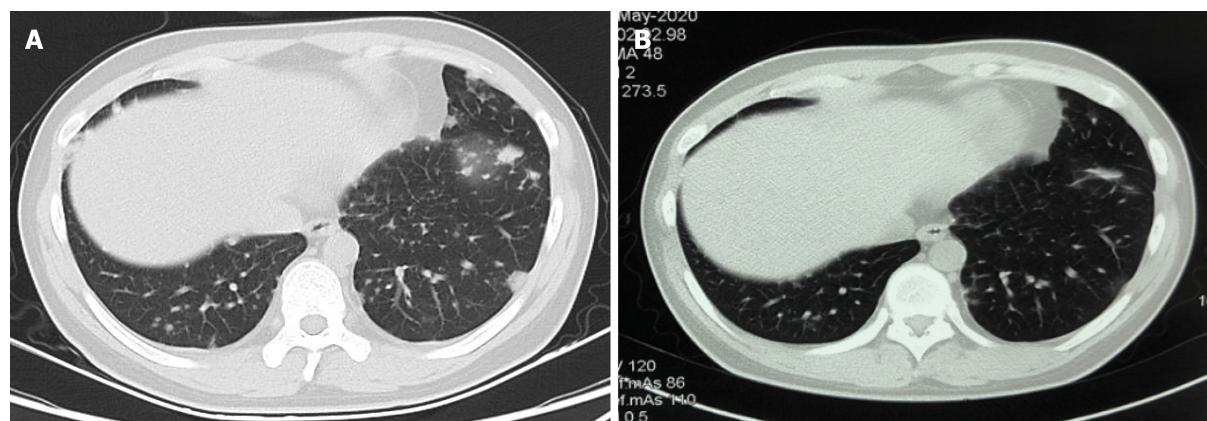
Computed tomography scan of the chest before and after combination therapy. A: Imaging features before treatment; B: Imaging changes after three cycles of treatment.
